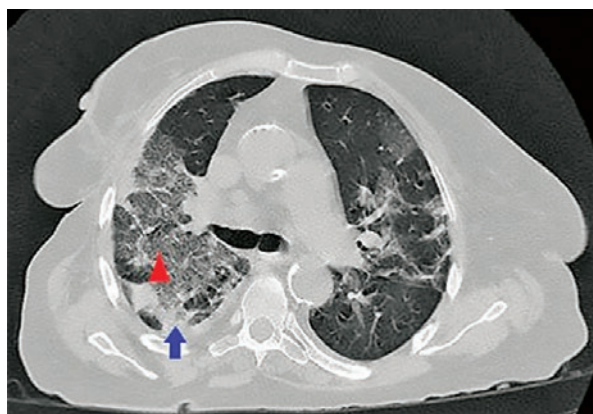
Chest CT in a patient with COVID-19 pneumonia on the tenth day of illness. Ground glass opacifications (red triangle) and peripheral consolidations are visible in the lung parenchyma of the right lung (blue arrow).
